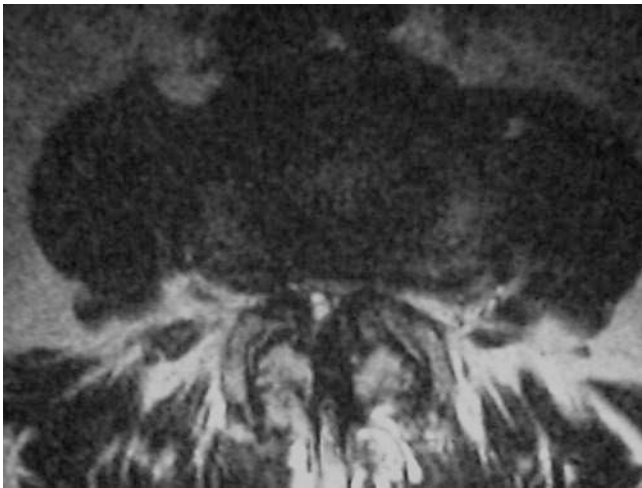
MRI spinal stenosis
